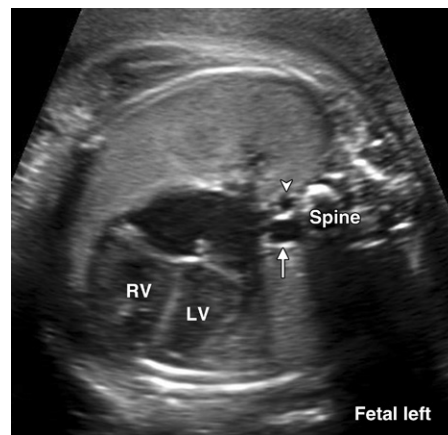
Normal azygos vein in a fetus at 35 weeks gestation. Axial US four-chamber view obtained during a growth follow-up scan shows the normal aorta (arrow). The smaller vessel beside it is the normal azygos vein (arrowhead). In this case, the hepatic veins and IVC were normal, and formal fetal echocardiography helped to confirm normal cardiac anatomy. With modern high-resolution equipment and slender maternal habitus, it is not uncommon to see a normal azygos vein in the late third trimester. This case does not need to be referred to fetal echocardiography. LV = left ventricle, RV = right ventricle.
